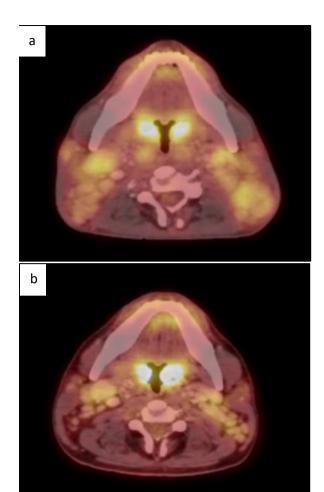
(a, b): Showing pre and post treatment PET CT Scans of the patient diagnosed with MCD after 6 cycles of chemotherapy (PR).
